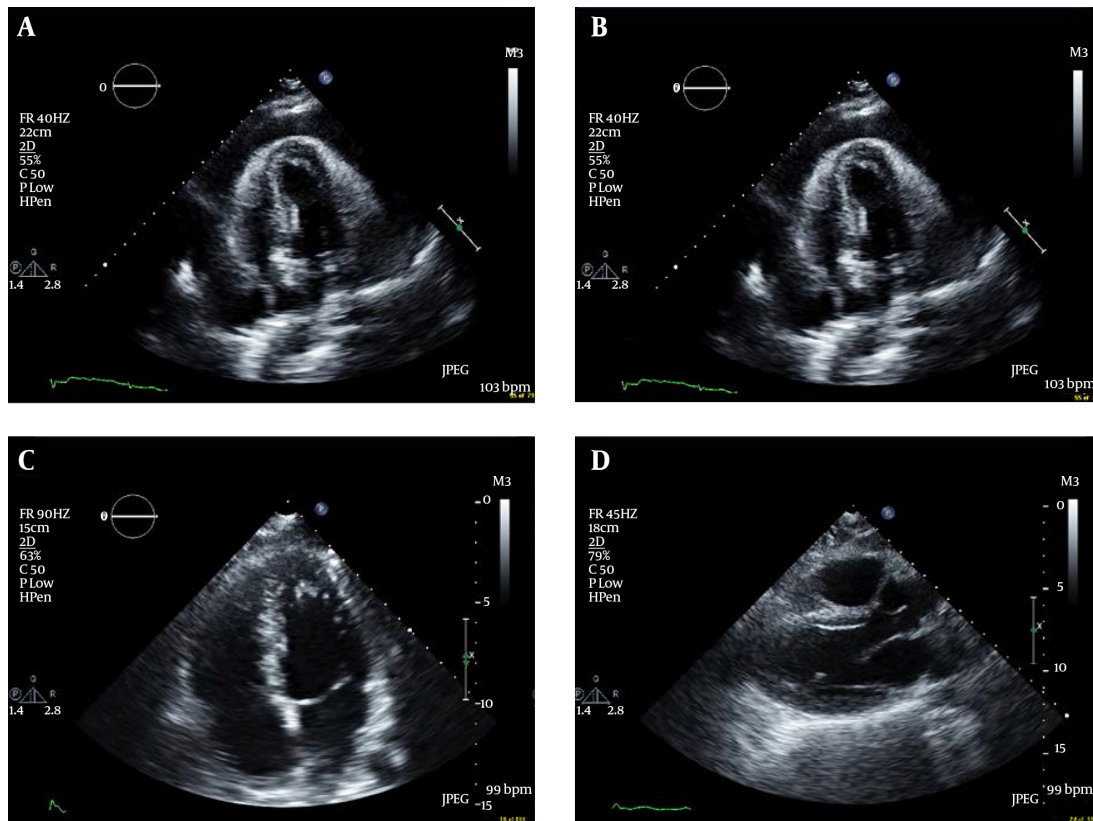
Transthoracic Echocardiogram Images Showing: A, four chamber view demonstrating large pericardial effusion; B, parasternal long axis view; C, four chamber view post pericardiocentesis and D, parasternal long axis post pericardiocentesis.
